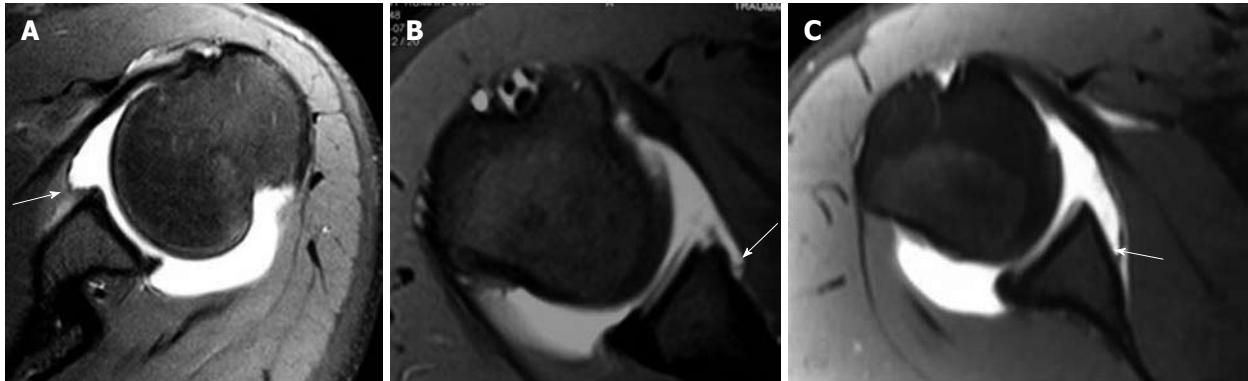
Magnetic resonance arthrographic axial T1-weighted fat-saturated images showing different types of attachment of anterior joint capsule. A: Type I ; B: Type II ; C: Type III (arrows).
